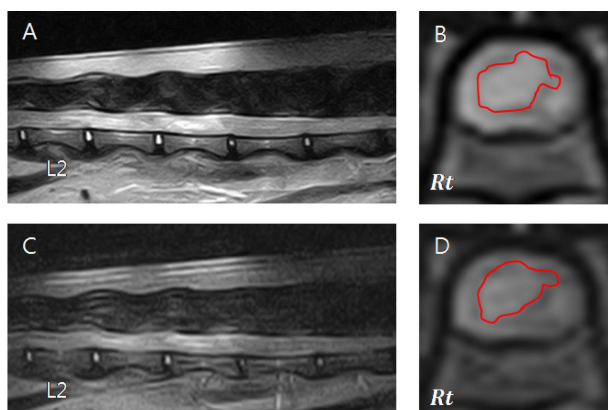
T1 weighted sagittal (A) and transverse (B) images and FLAIR sagittal (C) and transverse (D) images in case 2. The lesions are characterized by focal hyperintense intramedullary lesions on predominately grey matter of spinal cord over the L2 vertebral body to L5 vertebral body without neural compression.
